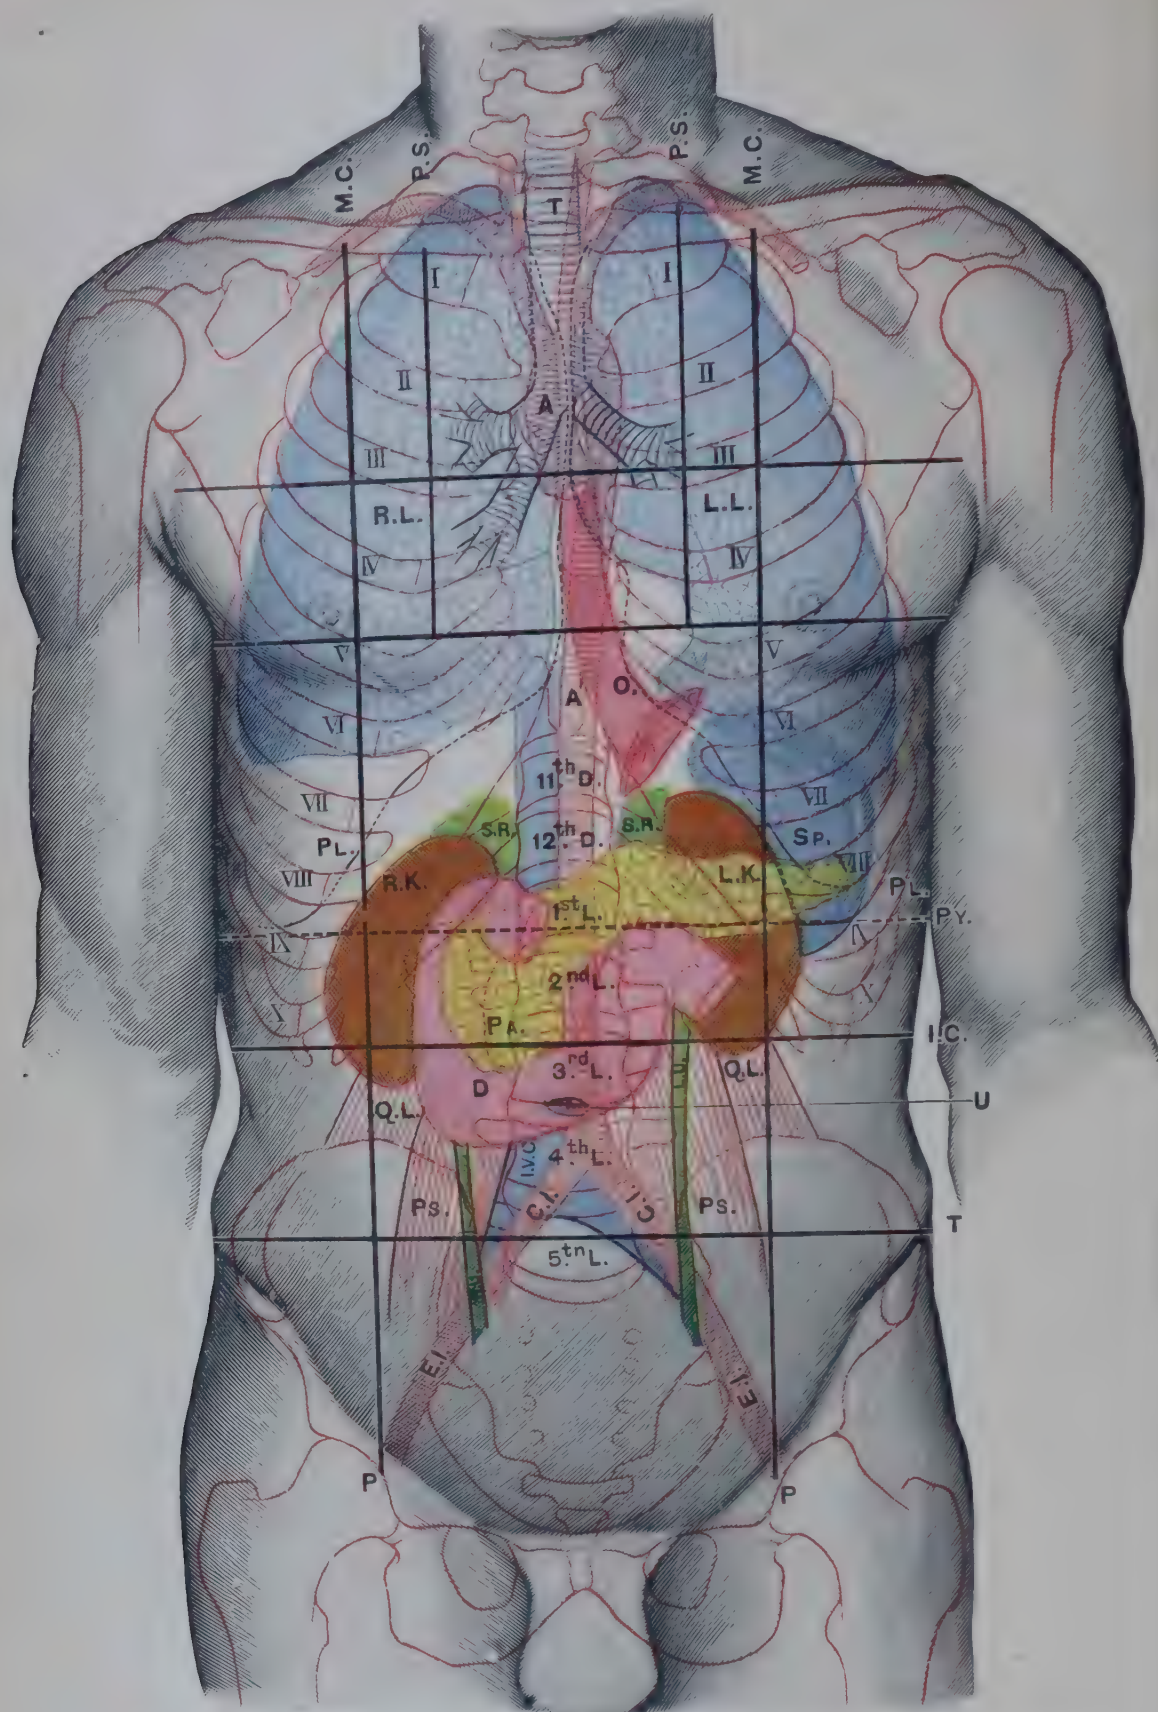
ANTERIOR ASPECT OF TRUNK, SHOWING SURFACE TOPOGRAPHY OF VISCERA.
